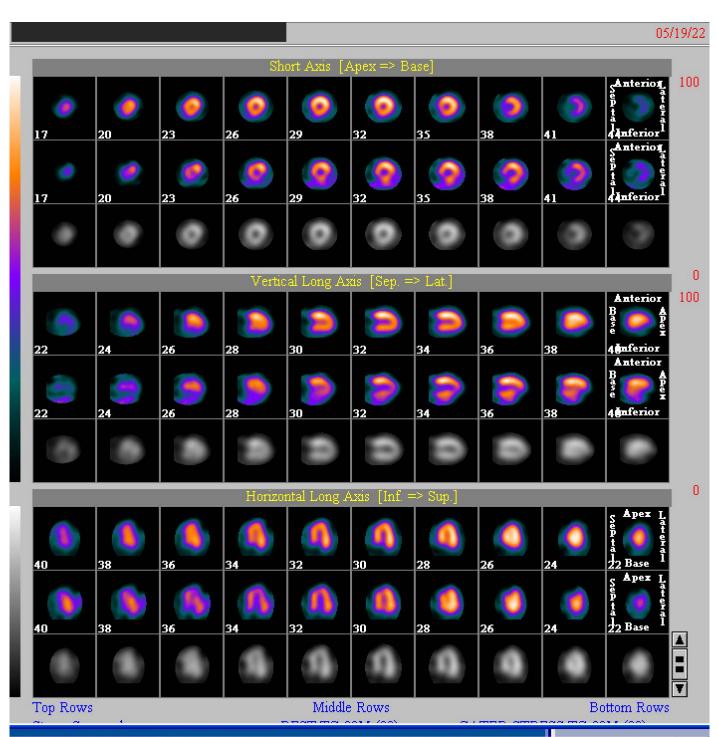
60 years old female with chest pain that led to the diagnosis of thymoma. SPECT myocardial perfusion scans were normal.
